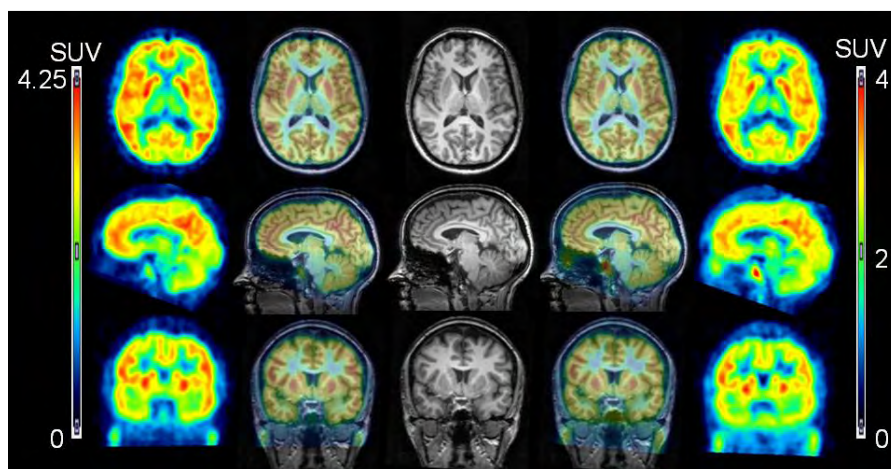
[^{11}C]MePPEP and [^{18}F]FMPEP- d_2 in human brain. PET images averaged from 40 to 80 minutes after injection of [^{11}C]MePPEP (far left column) and from 30 to 60 min after injection of [^{18}F]FMPEP- d_2 (far right column) and coregistered to the subject's MRI (middle column). PET and MR images are overlaid between their respective columns. All images are from the same subject. Standardized uptake value (SUV) corrects for body weight and injected radioactivity.
